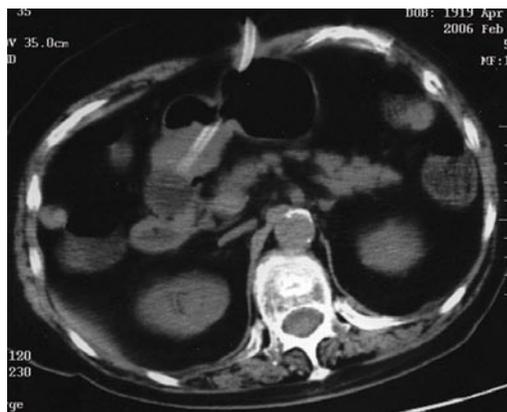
A plain CT scan demonstrating the PEG-tube balloon in the second portion of duodenum.
